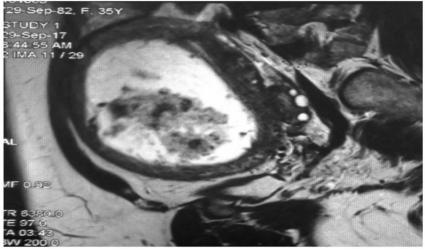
MRI pelvis showing enlarged uterus with a large heterogeneously enhancing lesion in anterior myometrium displacing endometrial cavity posteriorly; likely intramural fibroid showing cystic degeneration.
